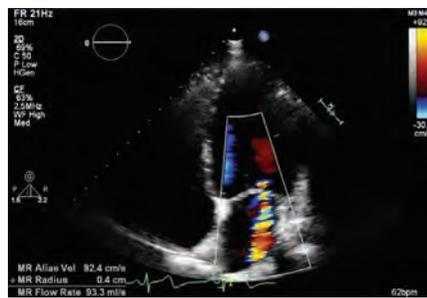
Mitral regurgitation with color doppler echocardiography.
